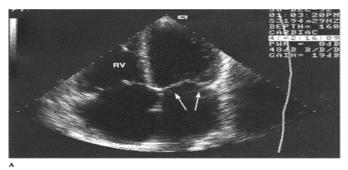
Papillary muscle dysfunction in patient with inferior infarction and right ventricular infarction. (A) Two-dimensional echocardiography, four-chamber view.
